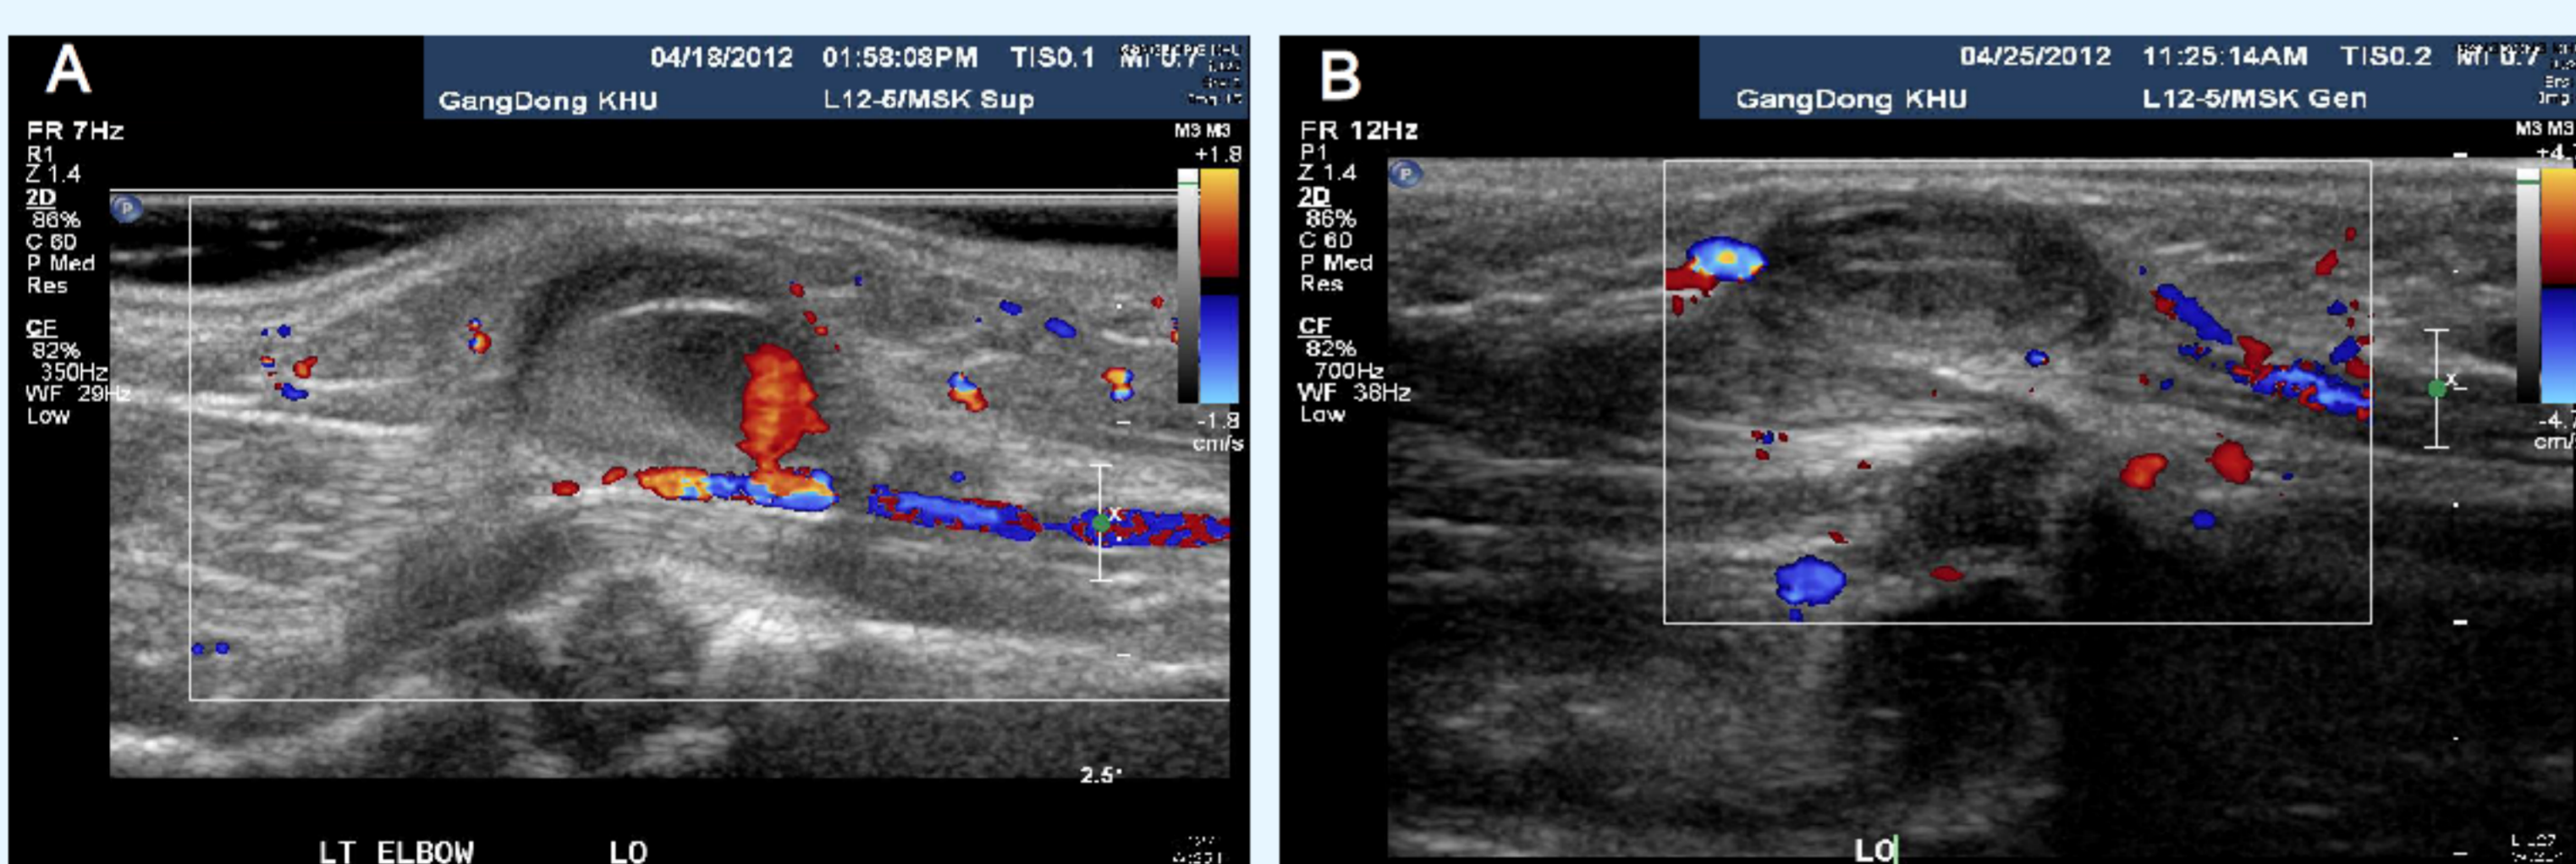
(A) Ultrasonography showed pseudoaneurysm from left brachial artery, that was 1.4cm in size and neck 1.0cm in size, (B) Follow-up ultrasonography was performed at 7 days after initial US-guided compression and coagulation factor administration. Findings showed thrombus in pseudoaneurysm and no intralesional blood flow into the lesion from brachial artery.
